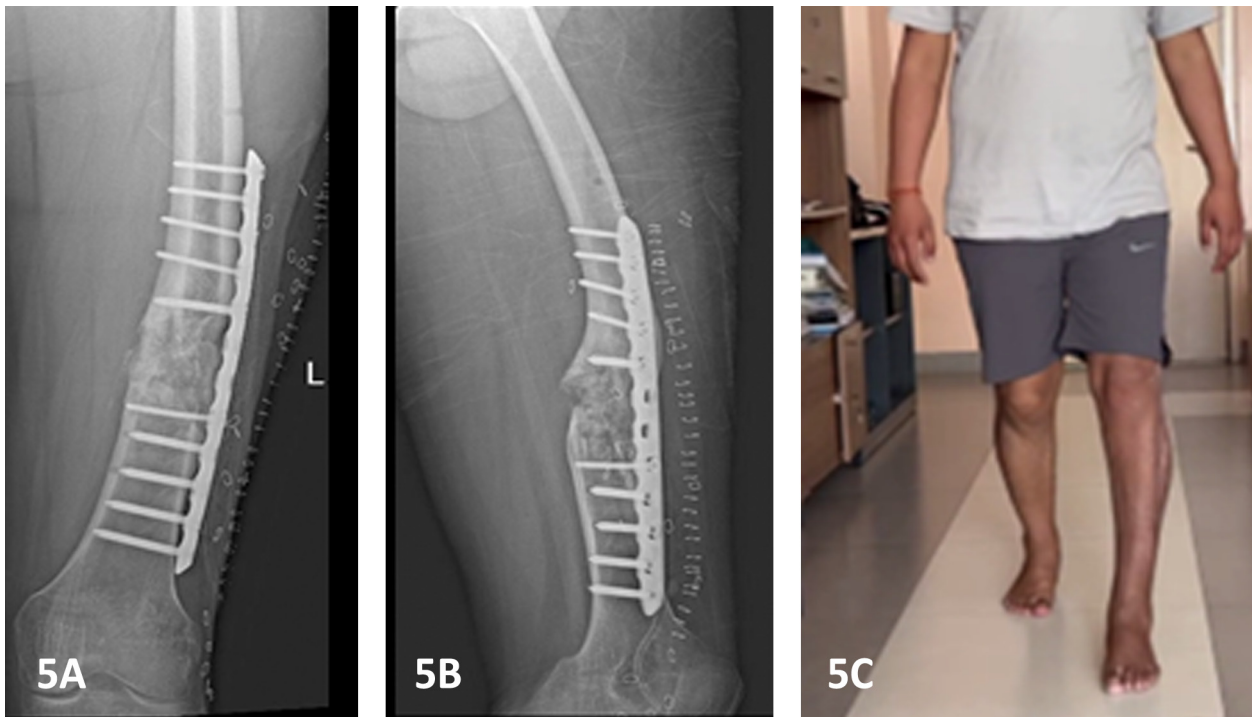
9-months follow up. A. antero-posterior B. lateral x-ray image showing adequate healing with plate and screws in situ. C. Plantigrade foot with corrected preoperative deformities.
